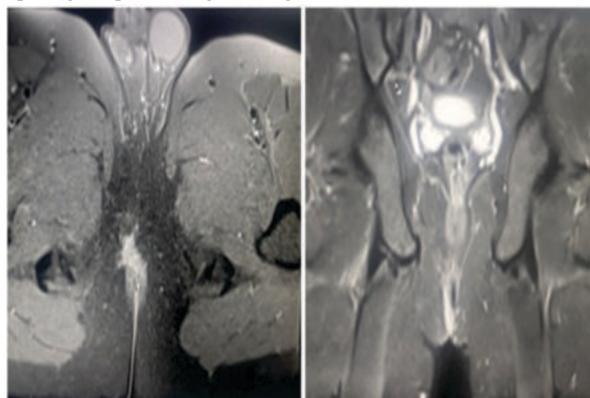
Axial and Coronal T2-weighted STIR Images show 'Transphincteric' fistulous tract with internal opening into anal canal at 11'O clock position, with its external opening in the perianal region on right side
